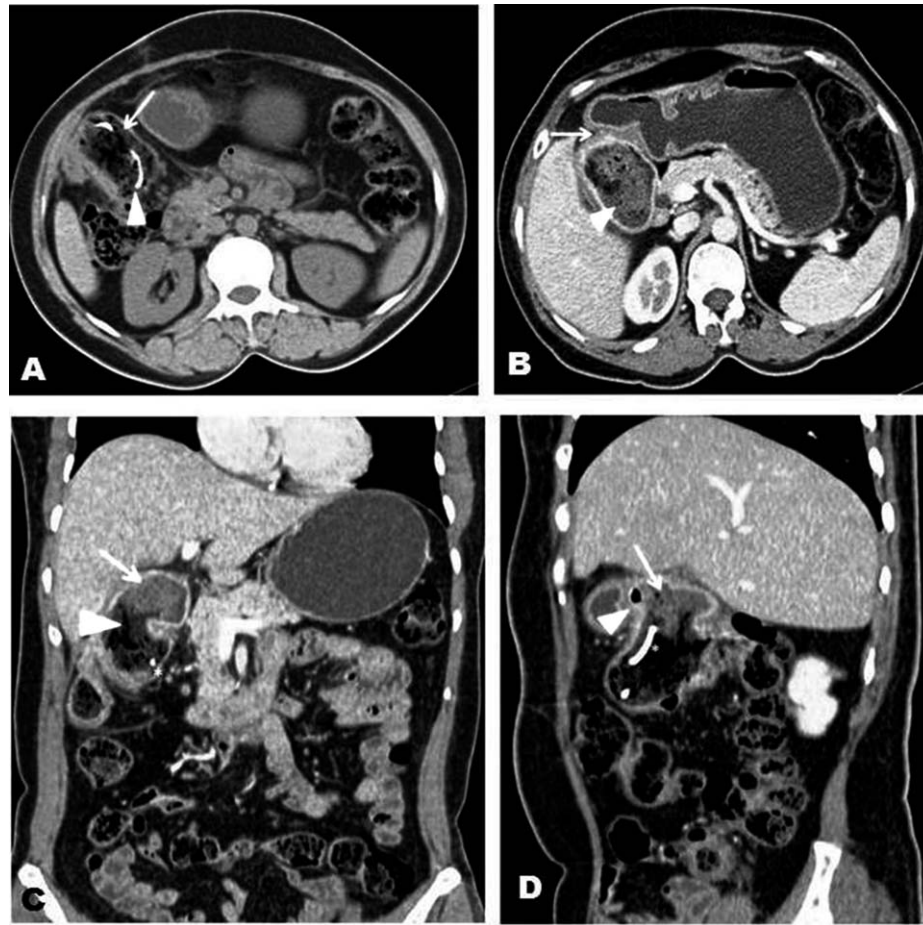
A 37-year-old woman, post open-cholecystectomy, with gossypiboma and coloduodenal fistula. (A) Nonenhanced axial CT scan of the abdomen showing intraluminal hypodense gas-containing mass (*arrow*) in the proximal transverse colon, with metallic density (*arrowhead*) in the mass consistent with surgical sponge having radiopaque marker strip. (B) Contrast-enhanced (venous phase) axial CT scan of the abdomen showing intraluminal hypodense gas-containing mass (*arrow*) in the proximal duodenum and the fistulous tract (*arrowhead*). (C) Contrast-enhanced (venous phase) coronal reformatted CT image of the abdomen showing an intraluminal hypodense gas-containing mass (*arrow*) in the proximal transverse colon with metallic density (*). A 2.5-cm fistulous tract (*arrowhead*) is seen between the proximal duodenum and the proximal transverse colon. (D) Contrast-enhanced (venous phase) sagittal reformatted CT image of the abdomen showing an intraluminal hypodense gas-containing mass (*arrow*) in the proximal duodenum and proximal transverse colon with metallic density (*). A 2.5-cm fistulous tract (*arrowhead*) is seen between the proximal duodenum and the proximal transverse colon. [Siemens Sensation 64 Multislice CT, 250 mAs, 120 kV, 2-mm slices: oral contrast—30 mL meglumine diatrizoate (Urografin) 60% diluted in 1 L water; intravenous contrast: meglumine diatrizoate (Urografin, Erlangen, Germany) 60%, 50-mL bolus.]
